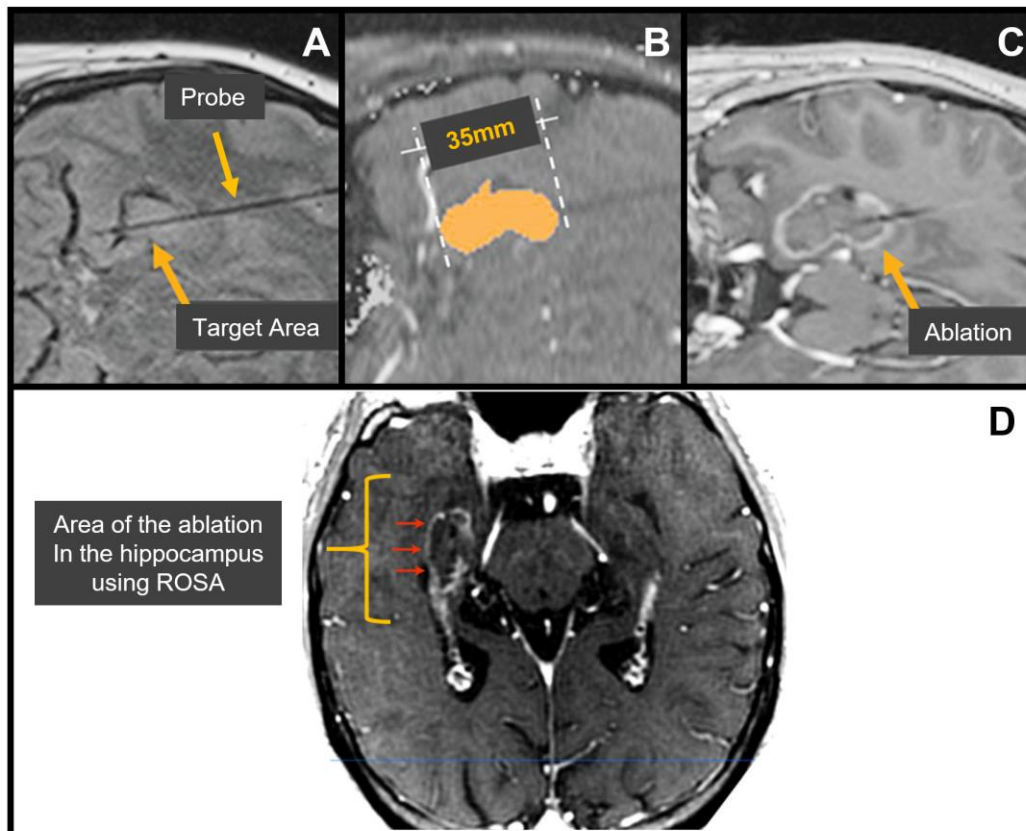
A) Probe insertion and estimation of the target region of the hippocampus [46], B) measurement of the irreversible Damage Zone (orange) during the ablation [46], C) ablated zone in a contrast enhanced T1 image [46], and D) Robotic-guided stereotactic EEG laser ablation of the hippocampus, as seen in a post-operative MRI [42].
